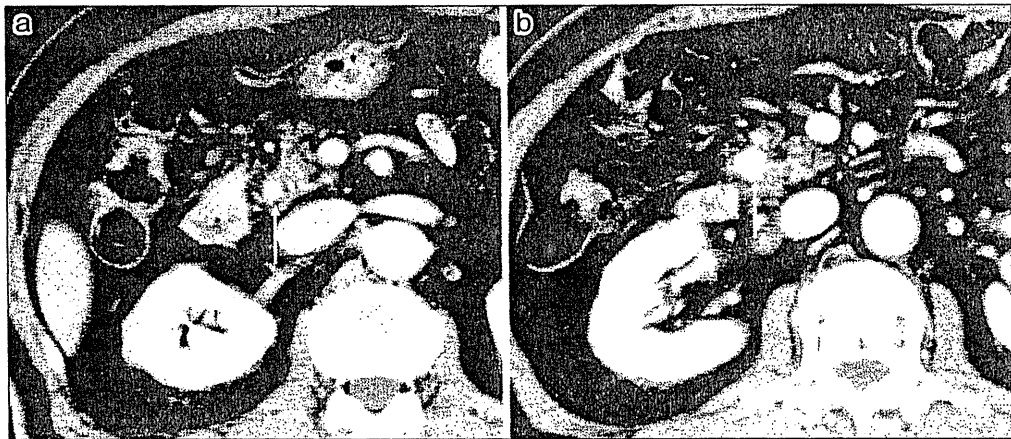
a: Abdominal CT showed an enhanced thickened inferior bile duct (arrow). b: CT showed an enhanced tumor in pancreas head (arrow).
